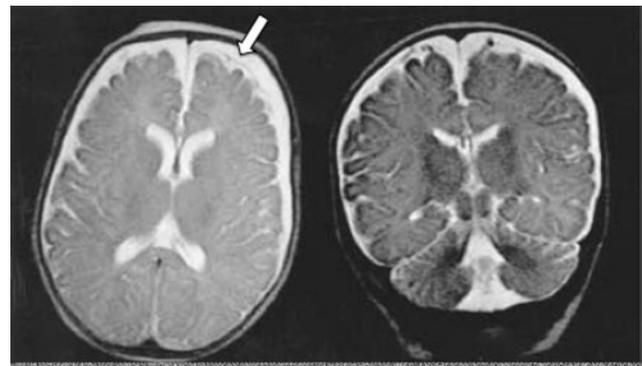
Chronic subdural hematoma. Axial and coronal T2-weighted high-resolution magnetic resonance images of the brain demonstrating bilateral chronic subdural hematomas in the late phase. Note the visible arachnoid layer (*arrow*) displaced downward by a fluid layer between it and the dura. Cortical vessels are not visualized within the fluid of this chronic subdural hematoma. Any significant amount of fluid in this space is pathologic.
